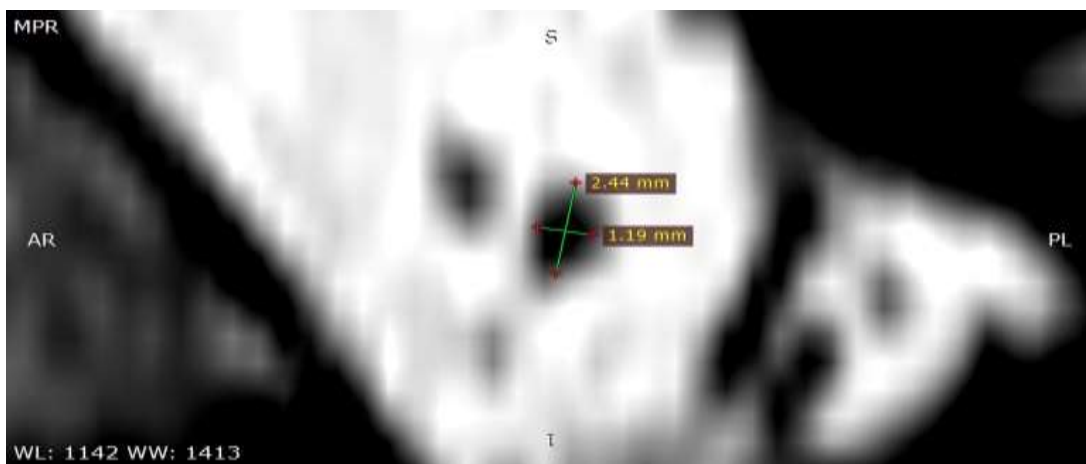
MPR MRI images for patient number 1 shows the axis of measurement in parasagittal orientation which is perpendicular to the long axis of the internal auditory canal.
